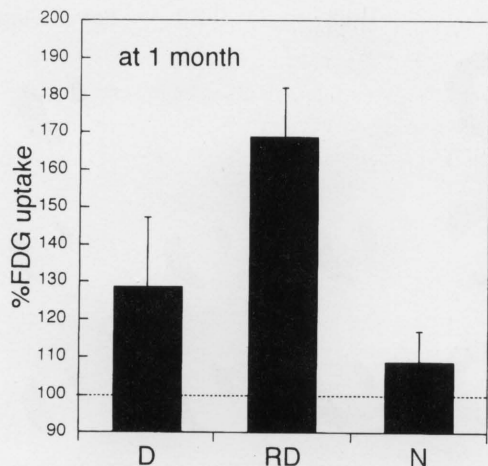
Normalized %FDG uptake during chronic phase in infarct-related area. D: area showing persistent perfusion defects in Tl images, RD: area showing redistribution in Tl images, N: area showing normal pattern in stress ^{201}Tl study.
